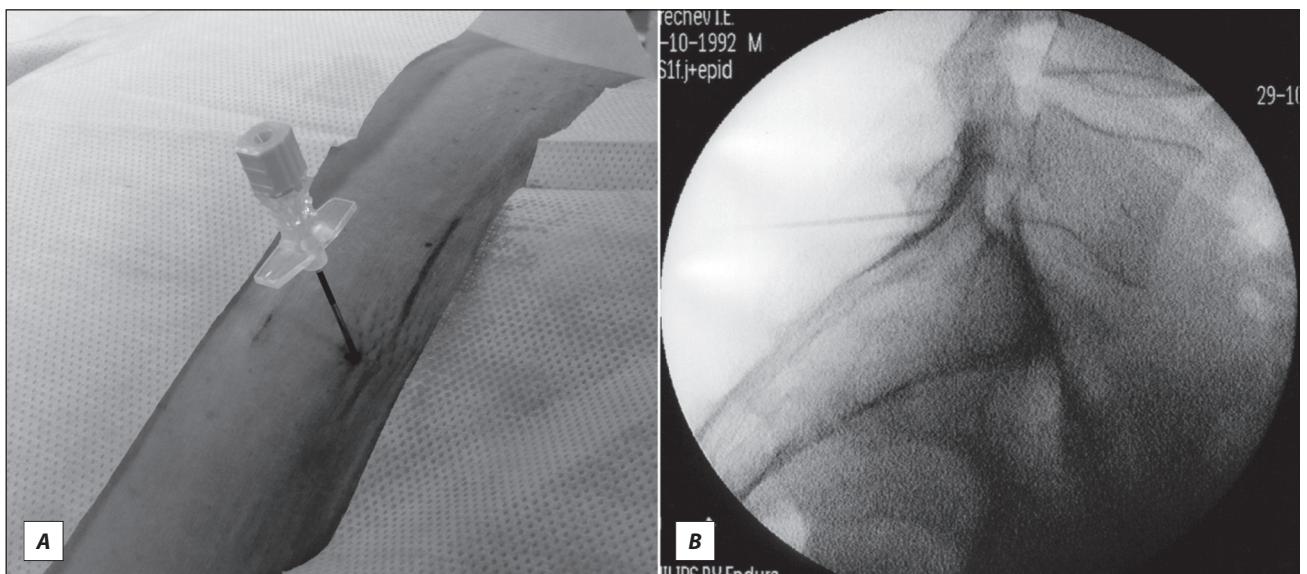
Interlaminar epidural corticosteroid injection at the L5S1 level (on the left: Tuohy needle is introduced into the interlaminar space; on the right: X-ray control of contrasting agent spread in the epidural space, lateral projection)
